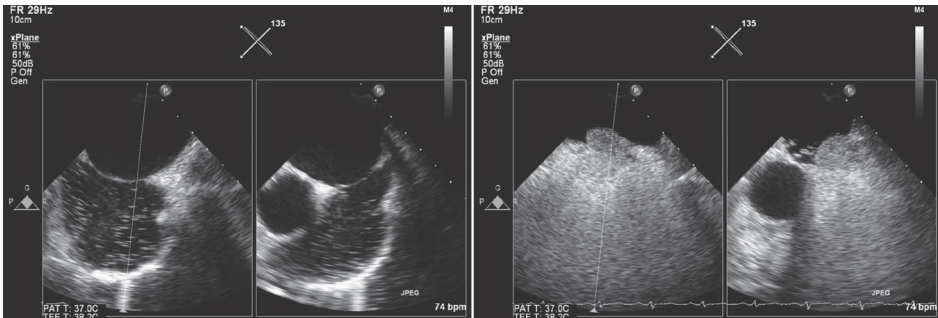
Contrast echocardiography. iRotate of 135° during transesophageal echocardiography allowing with xPlane simultaneous visualization of contrast passage through the foramen ovale in the bicaval 135° view (negative for right to left shunt) and the short-axis 45° view (positive for right to left shunt).
